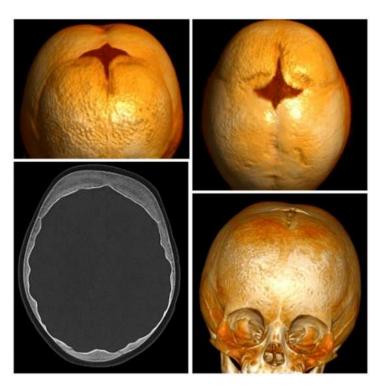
CT brain and skull of the child
